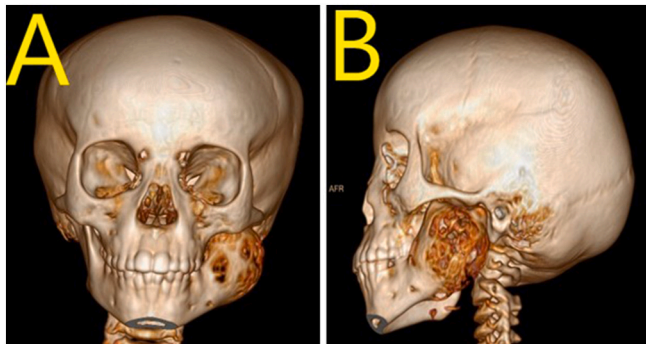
A and B 3-D reconstruction CT scans showing expansion of the left body-ramus of the mandible up to the coronoid/condylar regions with extensive cortical perforations.
